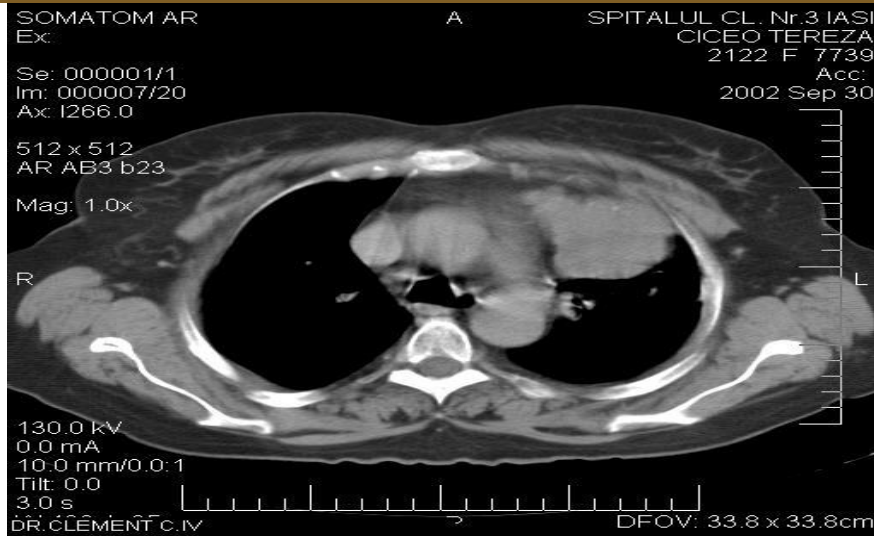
Thorax CT- invasive thymoma
